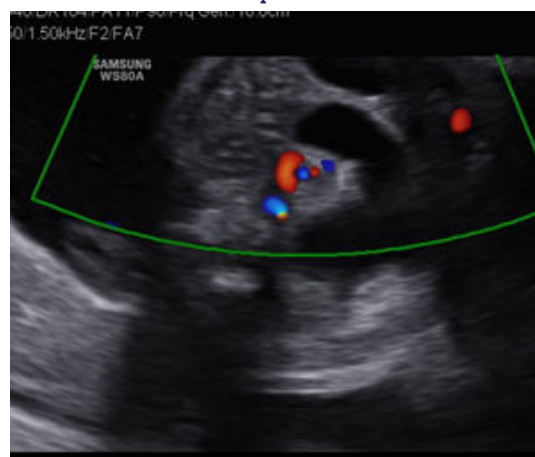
Color Doppler image show concentric small bowel loops surrounding the vascular pedicle with swirling of the mesenteric vessels (whirlpool sign).
